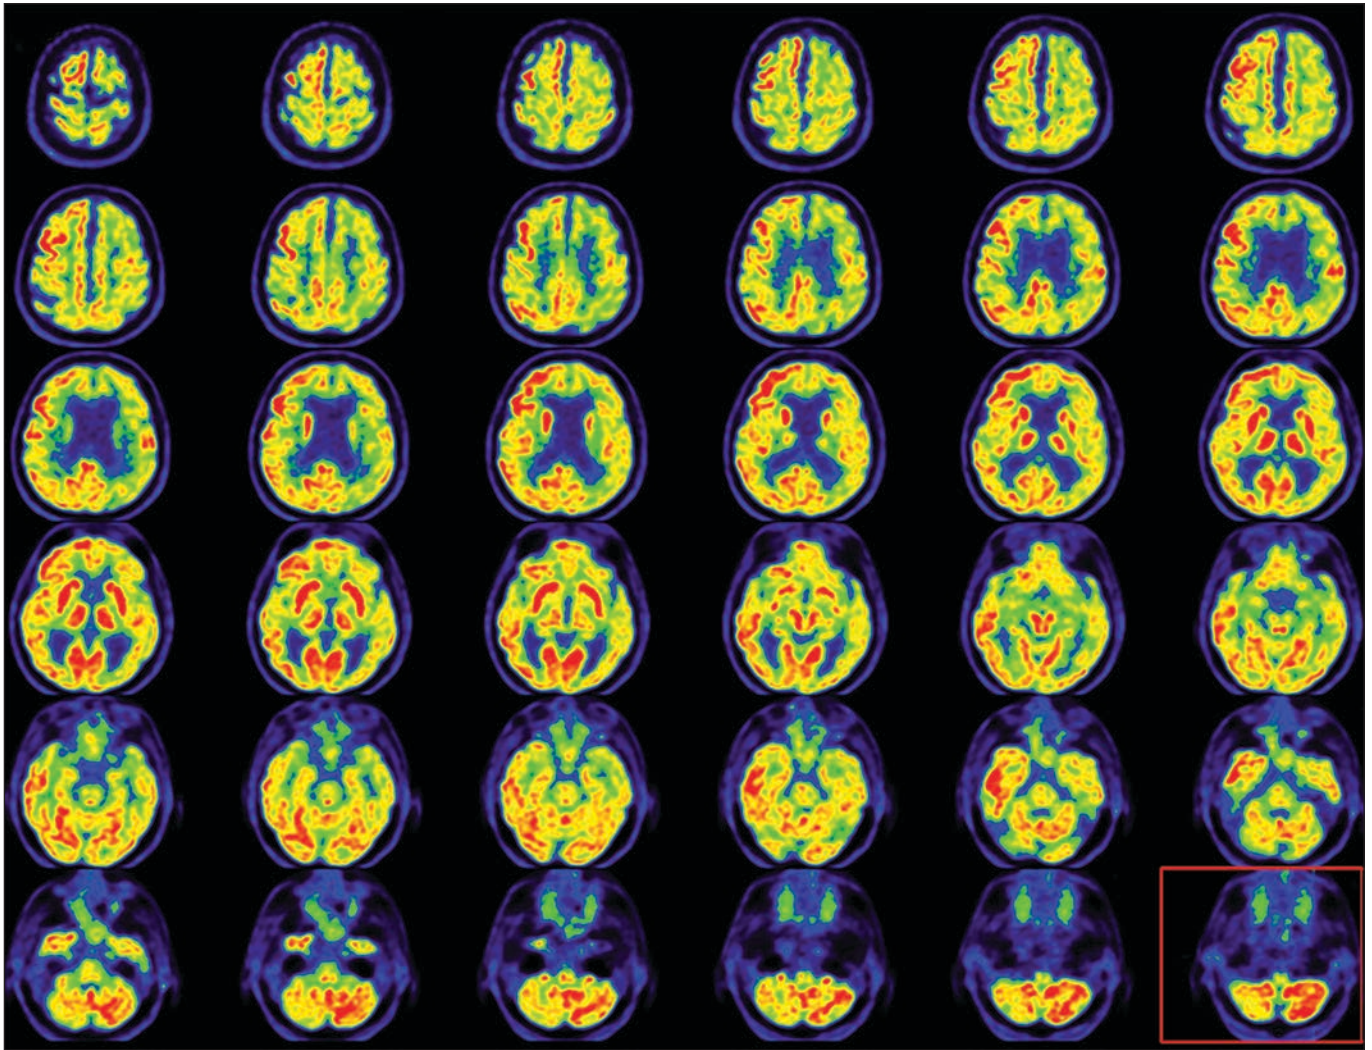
75-year-old man with corticobasal degeneration. Axial fusion PET and FLAIR images show abnormal FDG distribution pattern, hemispheric asymmetry, and decreased radiotracer uptake in nearly entire left cerebral hemisphere. Marked hypometabolism is evident, particularly in left frontoparietal region, as is decreased uptake in ipsilateral left basal ganglia and left thalamus. Corresponding hypometabolism is present in contralateral right cerebellar hemisphere. Findings are compatible with crossed cerebellar diaschisis. Red box indicates dominant clinical image of marked hypometabolism in cerebellum. There is asymmetry of radiotracer uptake consistent with crossed cerebellar diaschisis.
